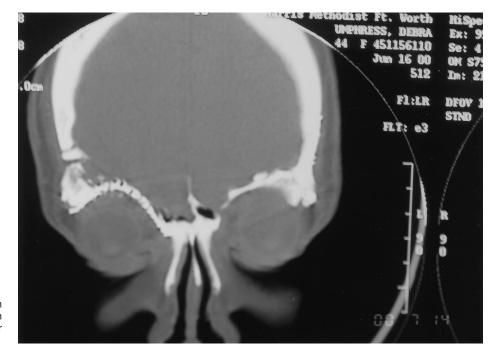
Postoperative coronal CT scan demonstrating adequate reconstruction of the three-dimensional orbital contour on the patient's right side.
